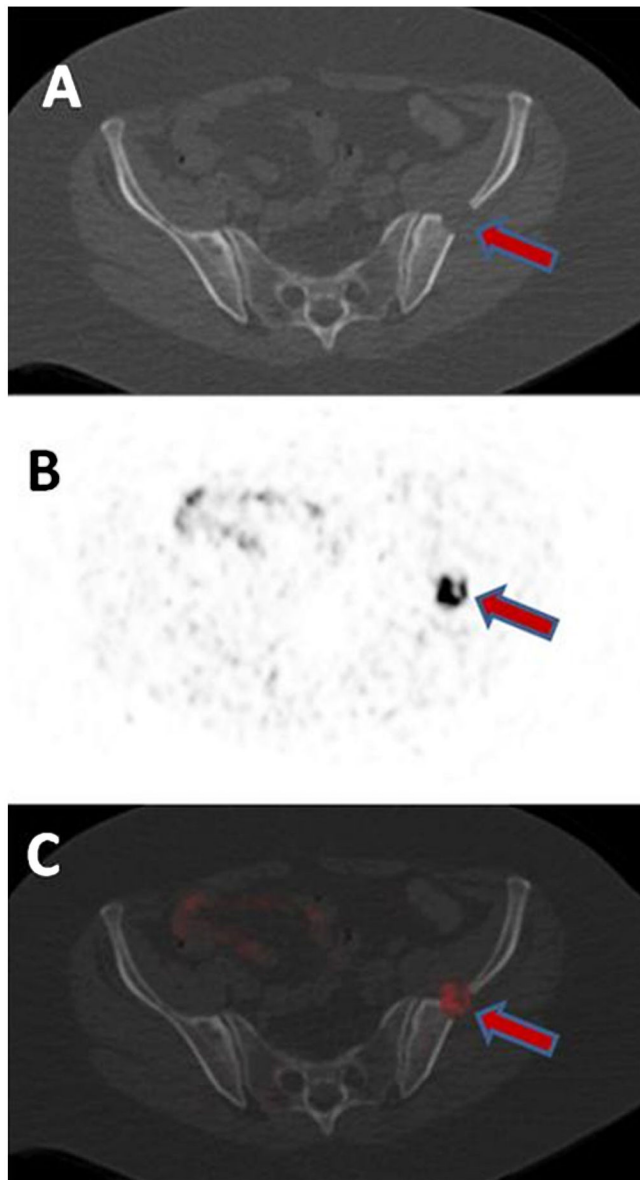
A 62-year-old female with metastatic ccRCC in the *left* ilium detected on CT (A). The lesions show uptake on axial ^{18}F -VM4-037 PET (B) and PET/CT (C) with SUVmax of 9.61.
